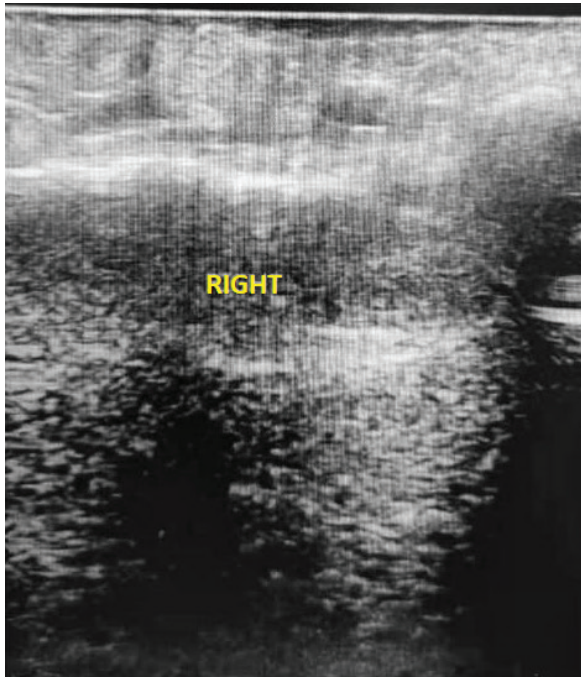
Preoperative ultrasound showing local soft tissue thickening of the right palm with multiple hyperechoic and hypoechoic areas.
